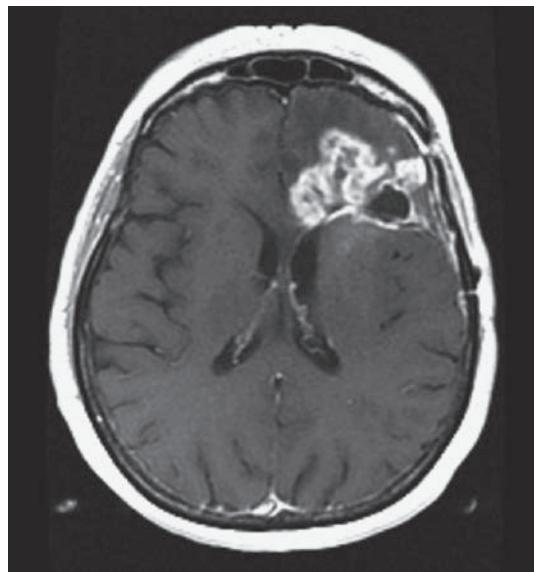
Postgadolinium T1 MRI of a large cystic left frontal glioblastoma.
